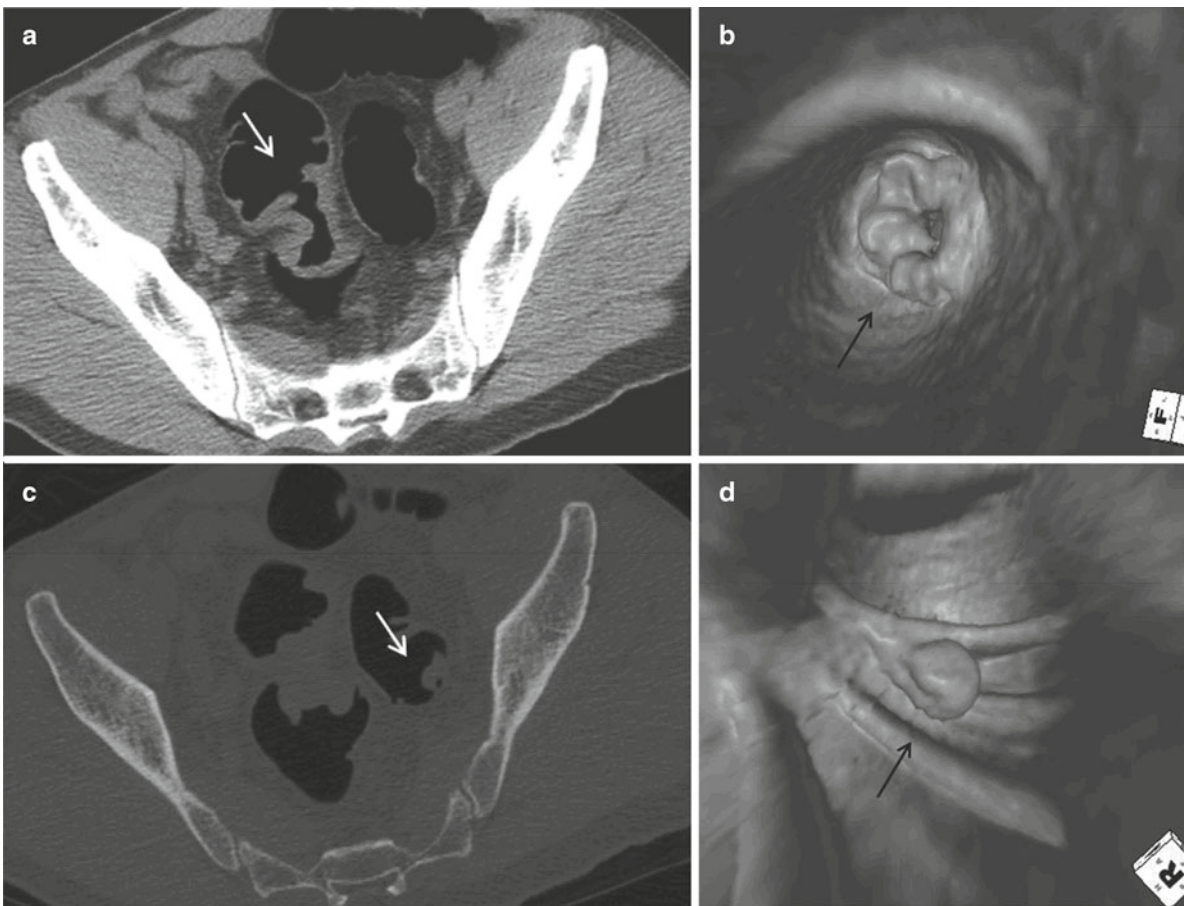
(a) CT colonography (CTC) 2D view of 4.5 cm annular constricting mass in the distal sigmoid colon (*white arrow*) on elderly patient. The gastroenterologist was unable to pass colonoscope proximal to mass. (b) Corresponding 3D endoluminal view of the mass
